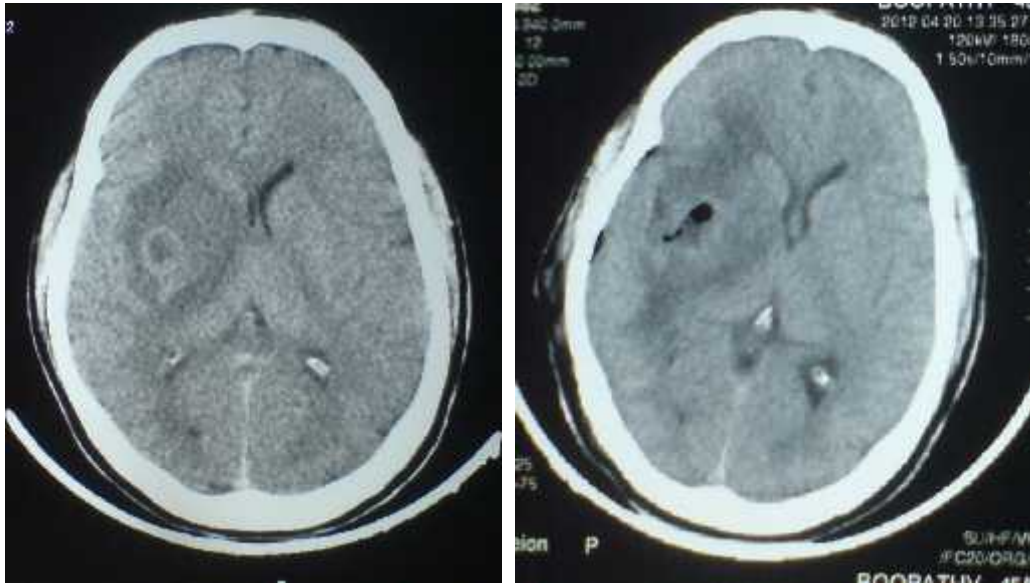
Pre-operative and post-operative CT images of brain abscess – Stereotactic surgery
